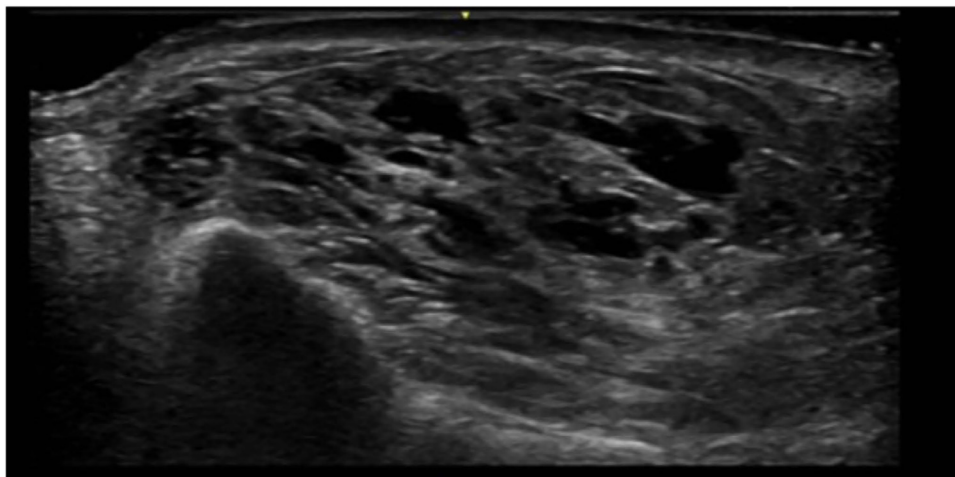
(a) Palpable nodular area on the dorsum of the hand following subcutaneous filling with a collagen biostimulator. (b) B-mode ultrasonographic image showing increased echogenicity of the subcutaneous tissue and hypoechoic thickening of the interlobular septa, suggestive of septal panniculitis.
